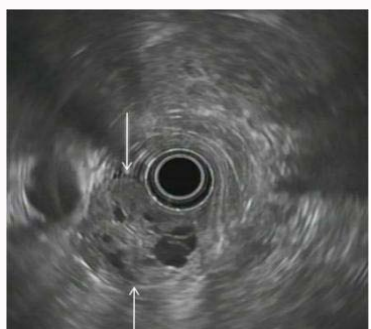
Endoscopic ultrasonography showed a cyst-solid lesion (arrow).
